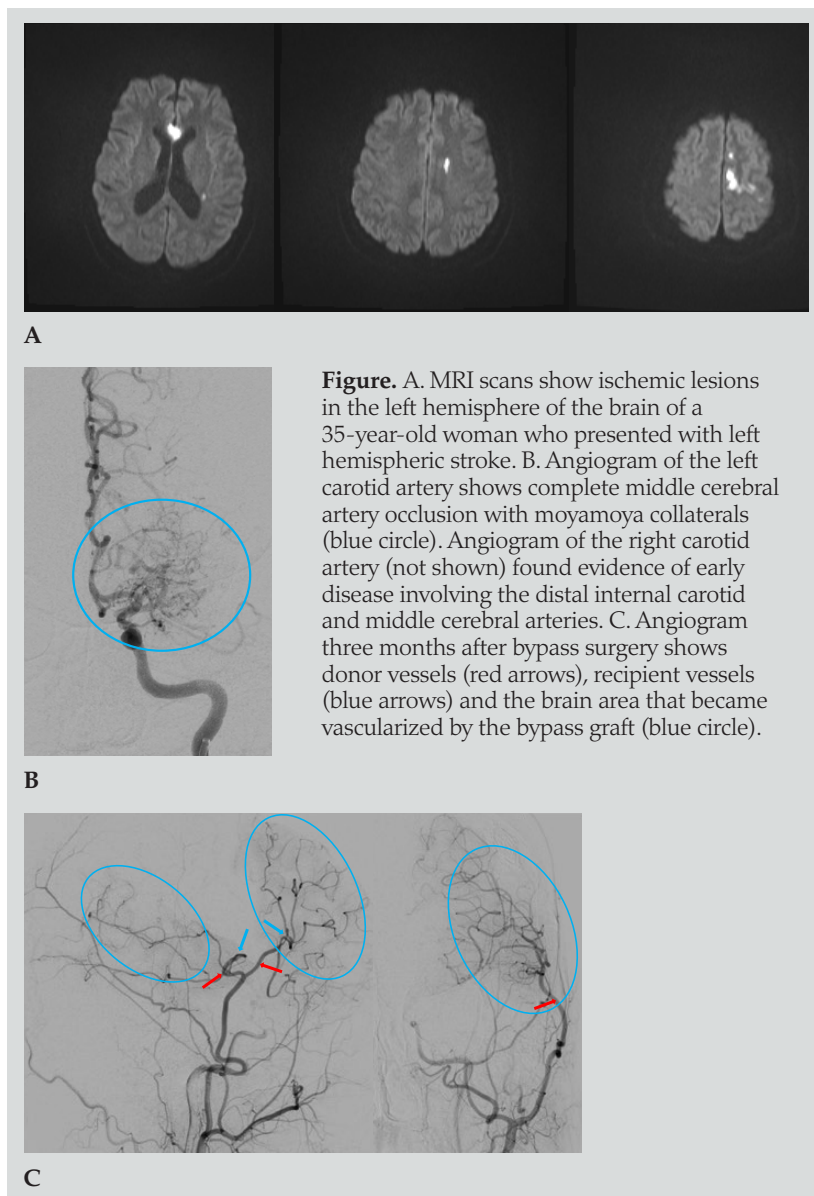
MRI scans show ischemic lesions in the left hemisphere of the brain of a 35-year-old woman who presented with left hemispheric stroke. B. Angiogram of the left carotid artery shows complete middle cerebral artery occlusion with moyamoya collaterals (blue circle). Angiogram of the right carotid artery (not shown) found evidence of early disease involving the distal internal carotid and middle cerebral arteries. C. Angiogram three months after bypass surgery shows donor vessels (red arrows), recipient vessels (blue arrows) and the brain area that became vascularized by the bypass graft (blue circle).
